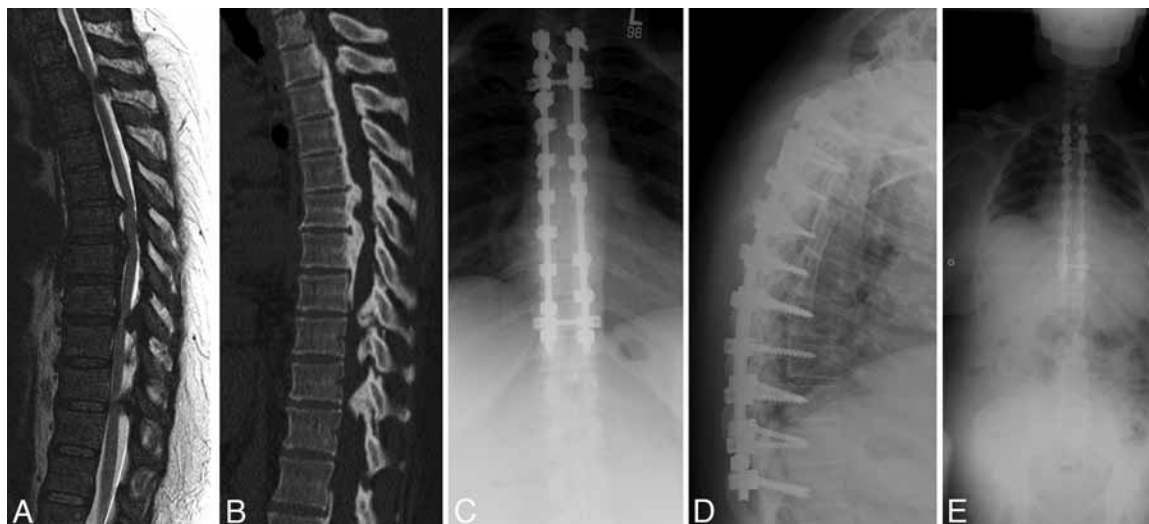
A: Preoperative sagittal T2-weighted MR image of the thoracic spine demonstrating multiple areas of cord compression. B: Preoperative noncontrast sagittal CT scan of the thoracic spine showing extensive thoracic cord compression caused by OPLL. C: Postoperative anteroposterior plain radiograph showing extensive segmental instrumentation following posterior decompression and fusion. D: Postoperative lateral radiograph depicting decompression and segmental instrumentation for treatment of OPLL. E: Postoperative 14 × 36-in anteroposterior plain radiograph demonstrating segmental posterior instrumentation. The cervical, thoracic, and lumbar spines can be appreciated in this particular study.
